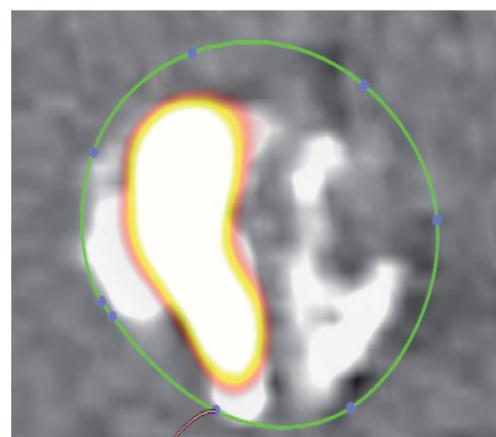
PET/CT of the aortic valve following administration of 18F-NaF. This tracer identifies regions of increased calcification activity in the valve (yellow/red areas). Areas of calcium already established in the valve are identified on the CT (white regions).
